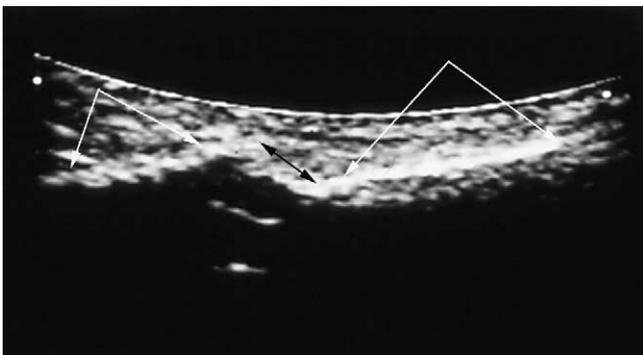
Ultrasound image of a fracture of the infraorbital rim. The black double arrow shows the fractured area. The white arrows mark the unfractured region.
